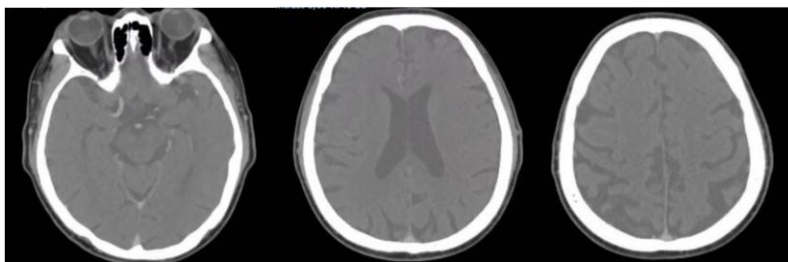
Brain CT scan with Contrast: No visible intracranial metastases
